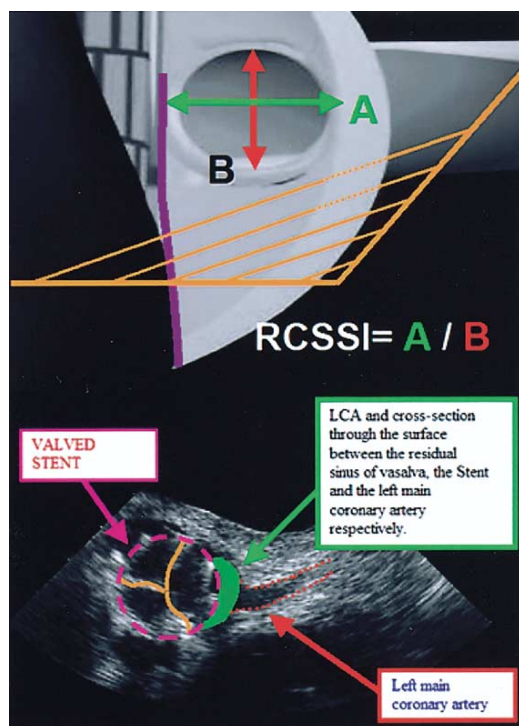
Intracardiac ultrasound after orthotopic valved stent implantation. LCA = left coronary artery.
